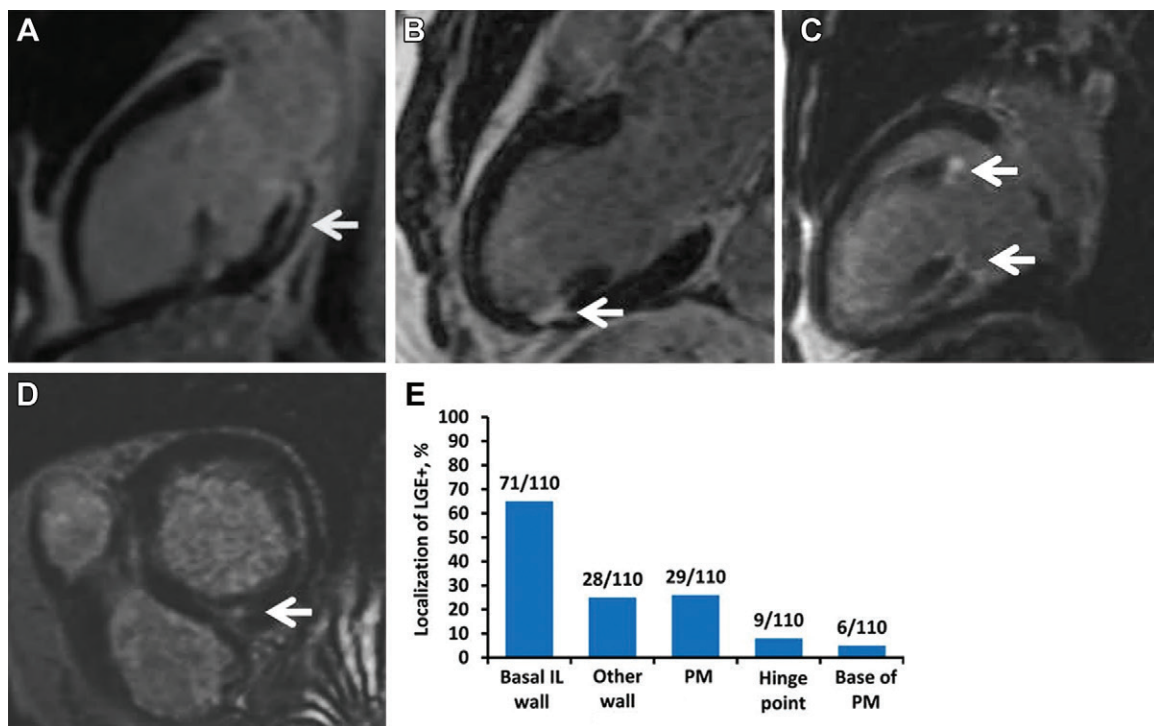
A prospective observational study of 400 patients with mitral valve prolapse was performed with 4-year follow-up. Late gadolinium enhancement (LGE) was found in 28% of patients. (A–D) MRI scans show four different types of LGE (arrows) among the 110 (28%) patients with LGE. (A) Linear basal inferolateral midwall LGE. (B) Nodular myocardial wall LGE at the base of the papillary muscle. (C) Tip papillary muscles LGE. (D) Small nodular inferior left-to-right ventricular hinge point LGE. (E) Chart shows distribution of the different types of LGE identified in patients with mitral valve prolapse. IL = inferolateral, LGE+ = LGE positive, PM = papillary muscle. (Adapted, with permission, from reference 27.)
